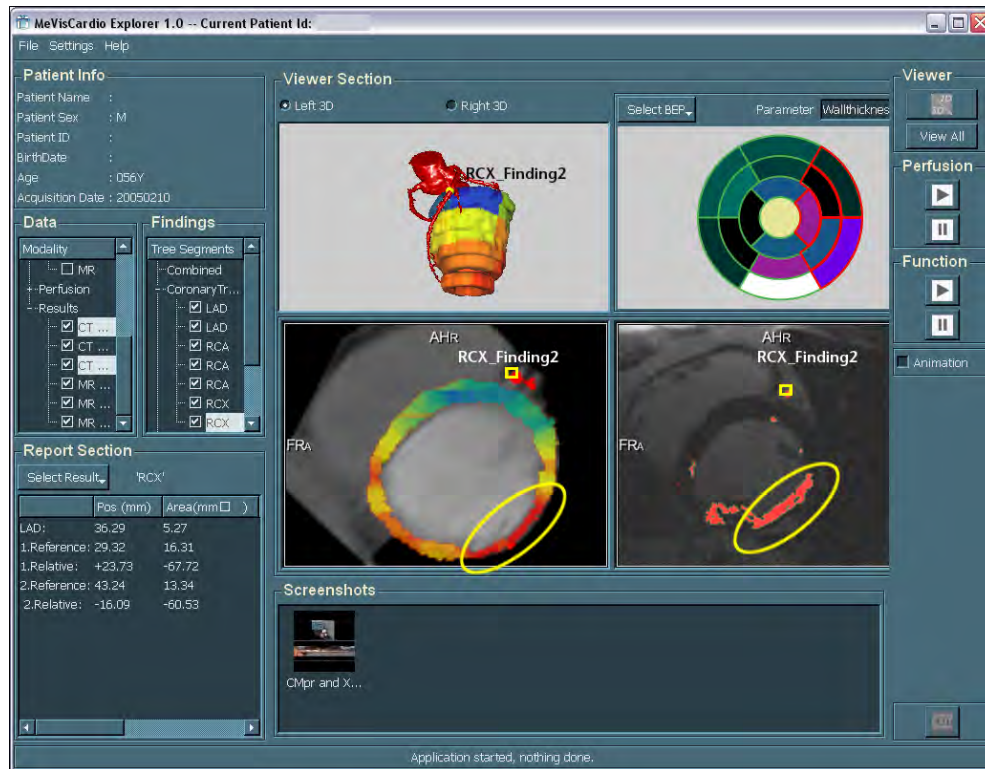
CardioExplorer by Kuehnel, Hennemuth, Oeltze, Boskamp, and Peitgen [2008]. Findings related to coronary arteries or myocardium can be selected from the menu on the left, and the visualization is parameterized by selecting the 3D viewing and 2D overlay components. The viewers on the left show a coronary tree and the wallthickness analysis derived from the CT data. On the right side the results of the MR late enhancement analysis are presented. The region corresponding to the selected stenosis measurement according to the AHA model is highlighted.
